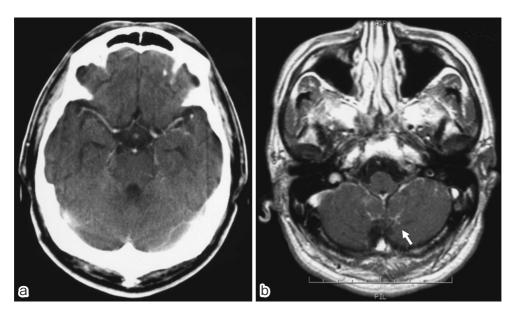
a: Brain CT: Brain CT scan shows no abnormalities. b: Brain MRI: MRI shows that the cerebellar sulcus was lightly enhanced. MRI does not show thickening of the dura-arachnoid, pia-subarachnoid space enhancement, rimlike enhancement of the ependyma of the lateral ventricle, or nodular enhancement in the subarachnoid space.
